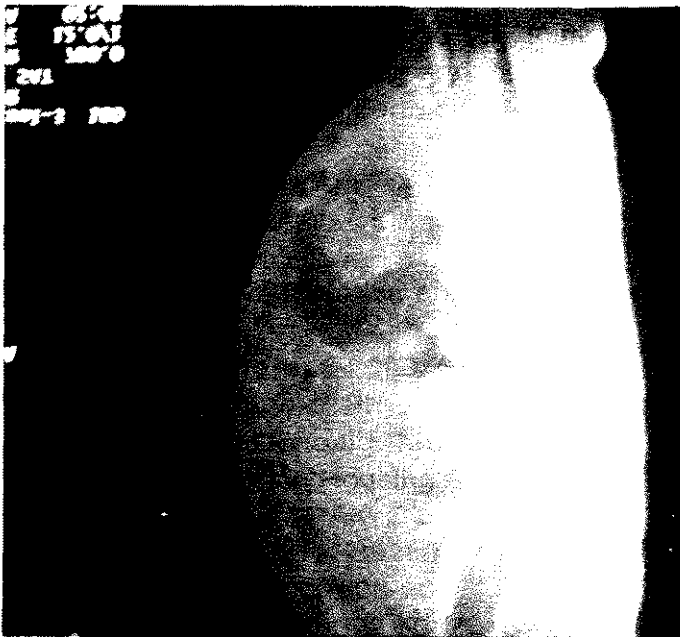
(a) & (b). The MRI of the lesion shows multi lobulated, encapsulated tumor plastered to deep inter muscular fascia. Overlying subcutaneous fat and skin is also infiltrated with multiple stippled lesions which represent plexiform, enlarged cutaneous nerves
